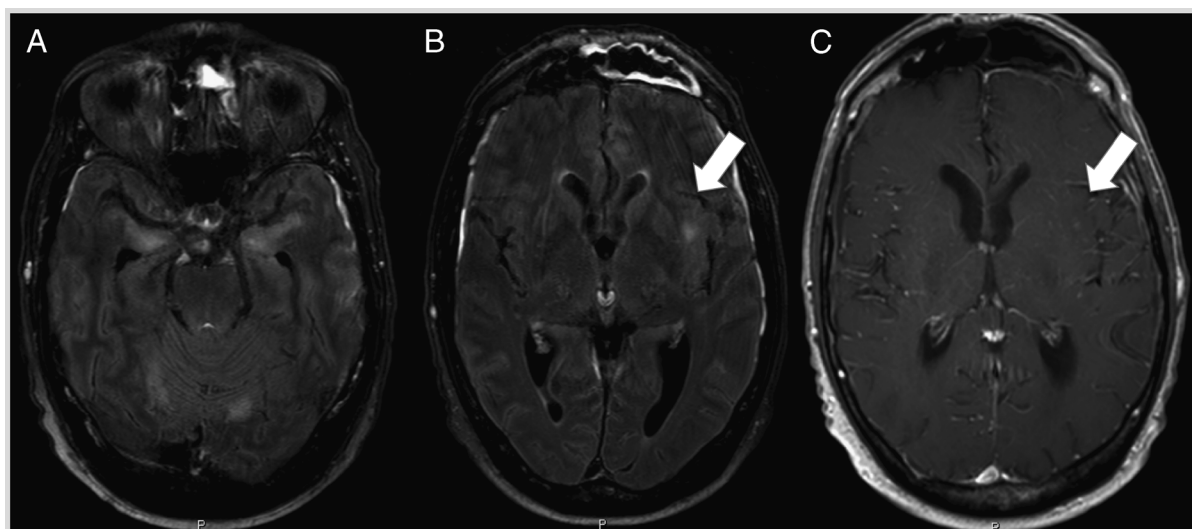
Fluid-attenuated inversion recovery (A, B) and T1 postgadolinium (C) sequences of MRI show hyperintense signal in the bilateral mesial temporal cortex (A) and the periventricular white matter of the left subinsular cortex (arrow, B). The signal abnormality in the left subinsular cortex is found to have very subtle enhancement on the postgadolinium image. Increased vascular markings are also seen in the right basal ganglia (arrow, C). While the enhancement is subtle, early intervention with corticosteroids reversed the encephalopathy in this case, providing further evidence that early inflammation was developing.
